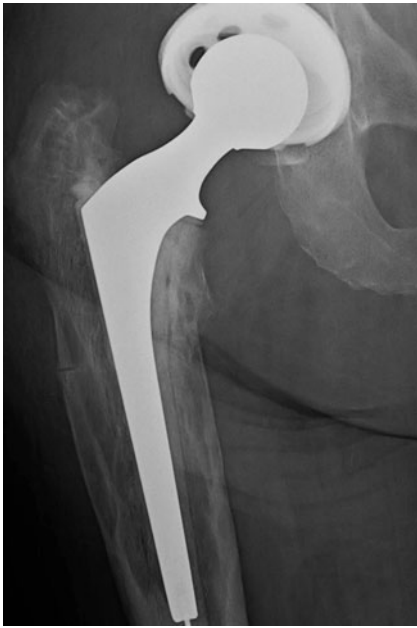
Magnification view of frontal radiograph of right hip, taken 8 weeks after prior imaging. Patient underwent interval right total hip arthroplasty
